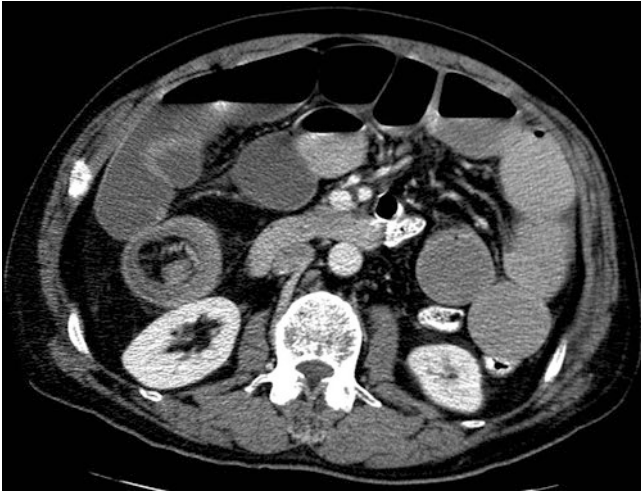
Small bowel obstruction from intussusception secondary to melanoma metastasis, located in the right abdomen in front of the right kidney as demonstrated on an abdominal CT (axial)
